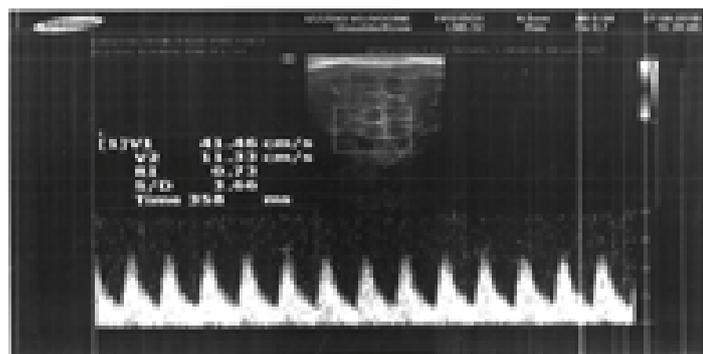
Resistance index, Normal Doppler wave.
